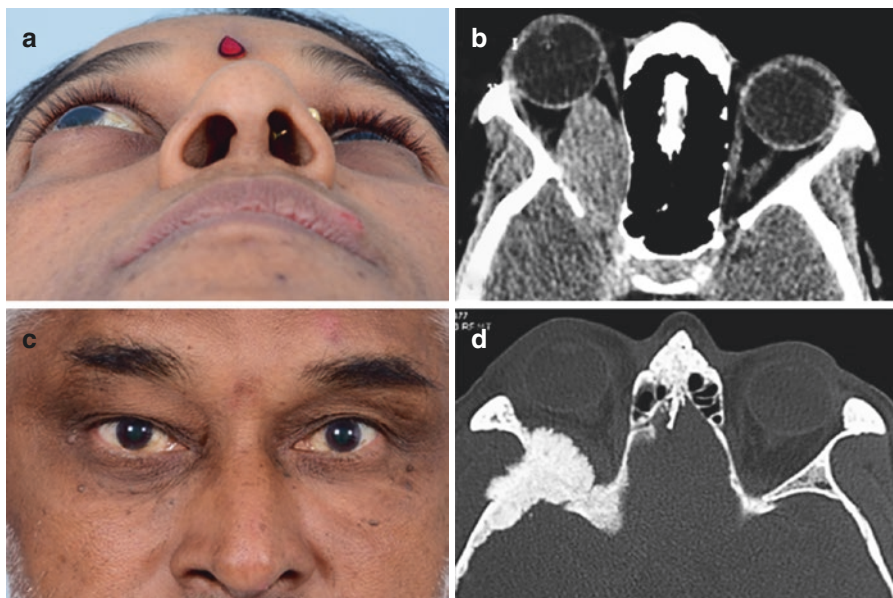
Orbital meningioma. (a) A 46-year-old female with Worm's eye view demonstrates left proptosis. (b) Axial CT orbit shows a homogenous fusiform mass along the course of the optic nerve extending with optic foramen widening. (c) A 52-year-old male with right proptosis and bulging of right temporal fossa. (d) Axial CT orbit shows left sphenoidal wing hyperostosis
